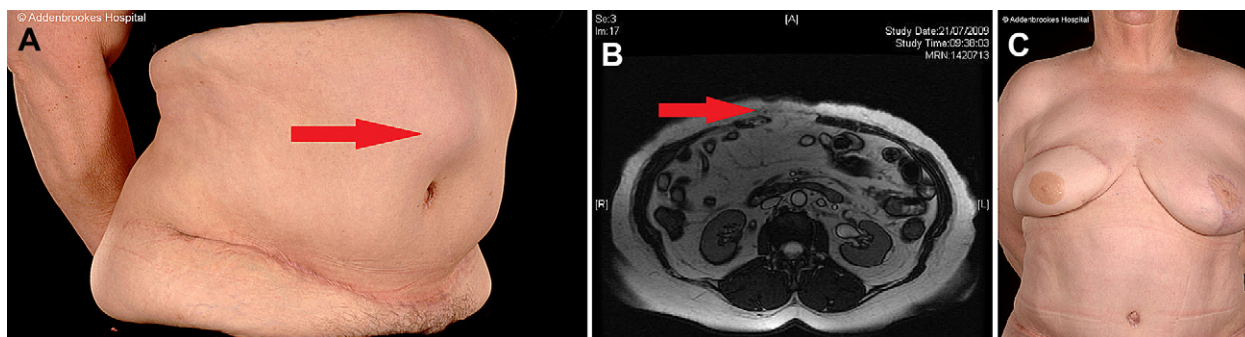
A. Ms C epigastric hernia (right oblique). B. Ms C MRI showing a large epigastric hernia. C. Ms C post-repair of the epigastric hernia.
